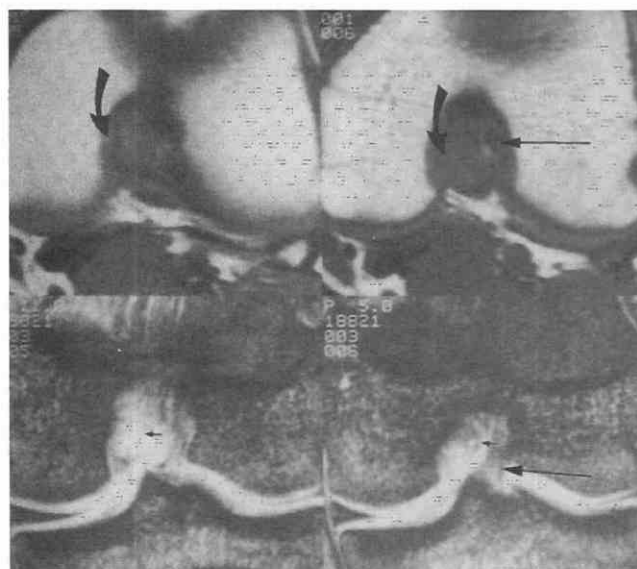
Tear of the posterior cruciate ligament (PCL) on axial and coronal views. Axial T1-weighted images show no identifiable PCL at its origin (*curved arrows*). Gradient-echo coronal images show no identifiable PCL at the intercondylar notch (*small arrows*). The normal anterior cruciate ligament is well defined (*large arrow*).
